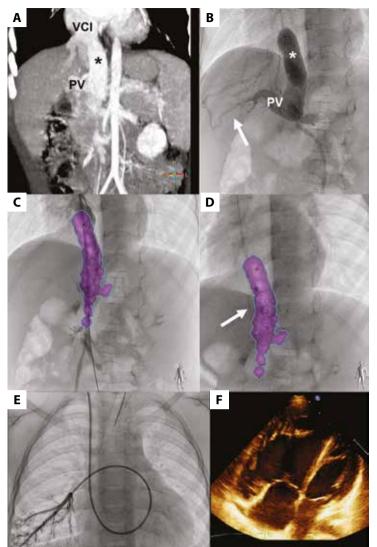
A. Computed tomography of the abdomen shows a large shunt (asterisk) between extrahepatic PV and VCI. B. Angiography through an inflated balloon (16 mm) catheter (asterisk) positioned across the shunt shows intrahepatic portal veins (arrow). C. Fluoroscopy fusion with CT derived model of the shunt (violet structure) — control angiography through the long sheet to confirm position. D. Amplatzer Vascular Plug II (arrow) positioning based on CT derived model overlay. E. Peripheral angiography shows decreased arborization of pulmonary arteries. F. Echocardiography: the enlarged right ventricle and the right atrium, the left ventricle compressed
